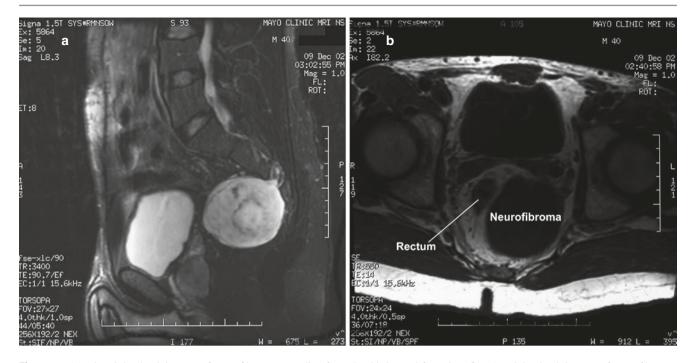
(a) T2 weighted pelvic MRI of neurofibroma extending from the third sacral foramina. (b) T1 weighted pelvic MRI of neurofibroma. (Reused with permission of Mayo Foundation for Medical Education and Research, all rights reserved)
